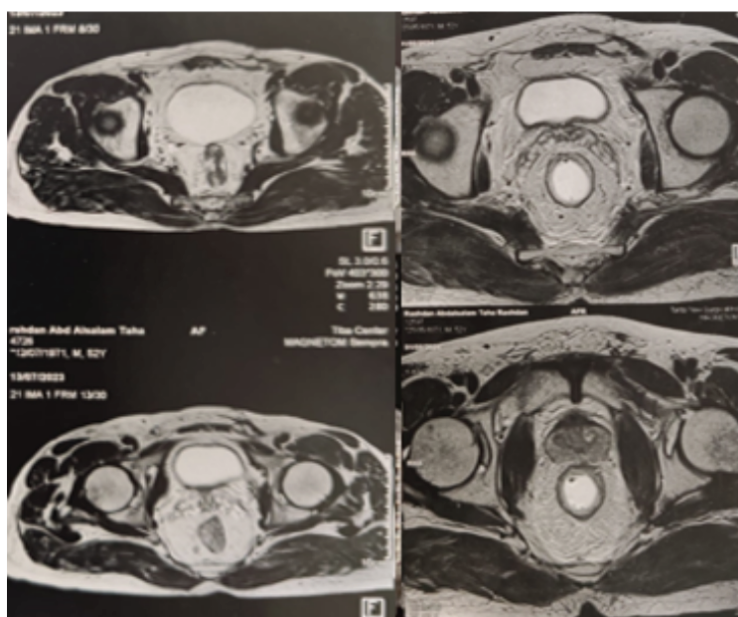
MRI showing response after TNT.
